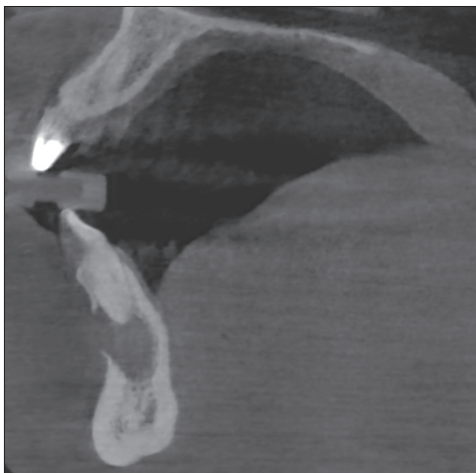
cone-beam computed tomography cross section demonstrating the size of the odontogenic cyst associated with the failing endodontic teeth in the mandibular anterior, with a lack of the facial plate noted
